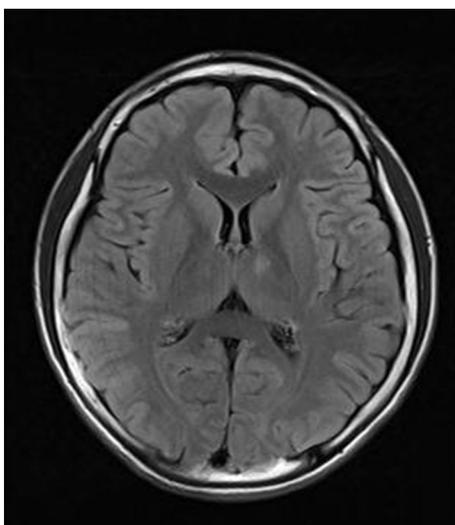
Patient 8. Brain MRI T2 FLAIR axial image showing hyperintense signal changes involving the posterior limb of the left internal capsule and left thalamus (arrow).
